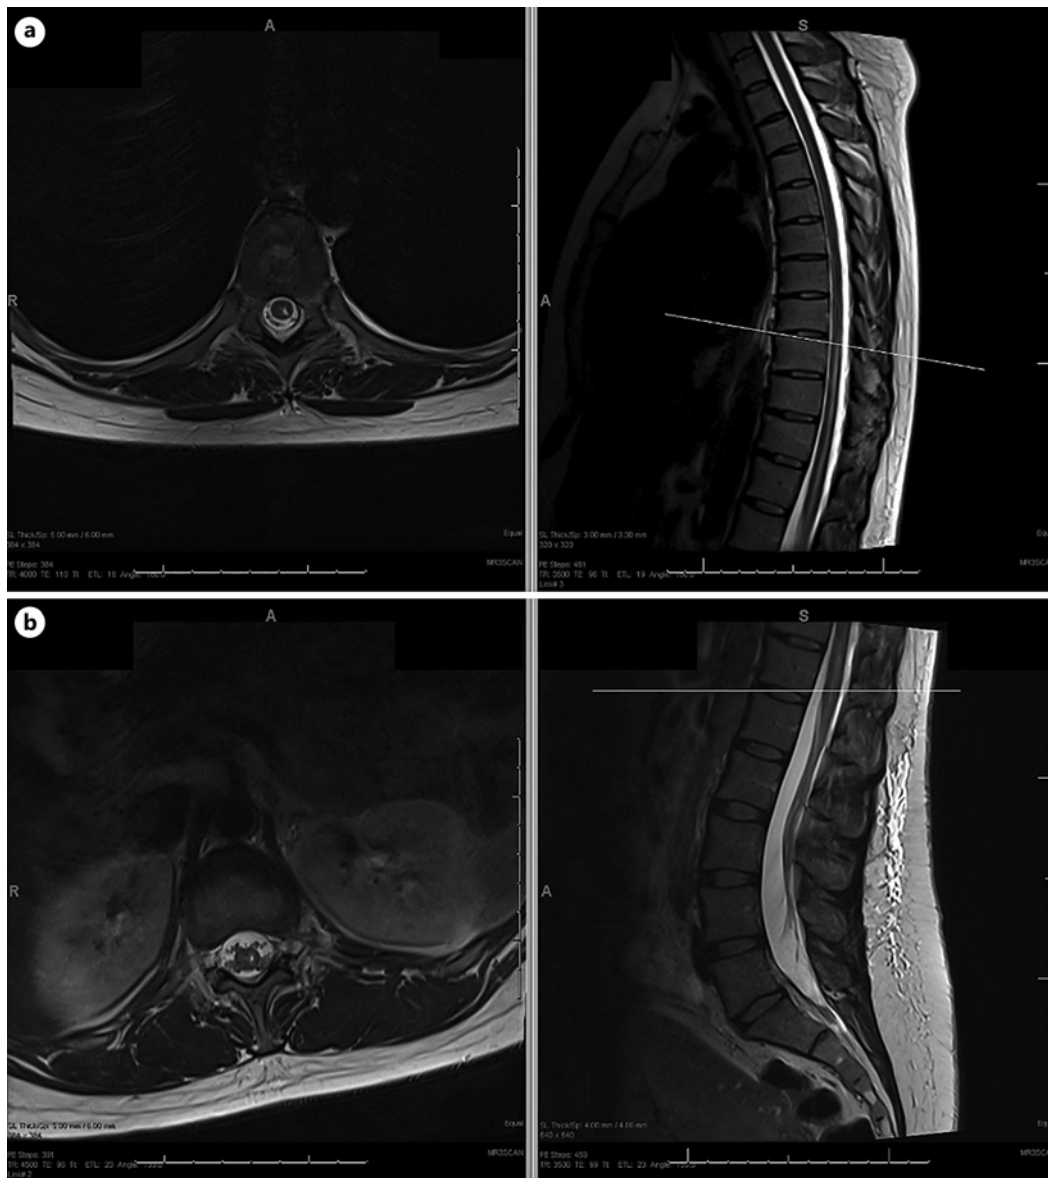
T2 MRI of the thoracic spine (a) and T2 MRI of the lumbar spine (b) demonstrating T2 hyperintensities within the left hemicord extending from T8 to the conus medullaris.
